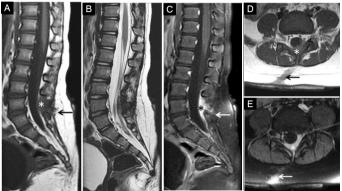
Magnetic resonance images of a 36-month-old girl with right paramedian lumbarDSCI at level L4 (Case 4). The DS tract is recognizable in the subcutaneous cellular tissue up to the epidural space (arrows) and an epidural phlegmon is highlighted with the contrast (asterisk). A. Sagittal T1 MRI. B. Sagittal T2 MRI. C. Sagittal T1 MRI with fat suppression and gadolinium. D. Axial T1 MRI. E. Axial T1 MRI with fat suppression and gadolinium.
